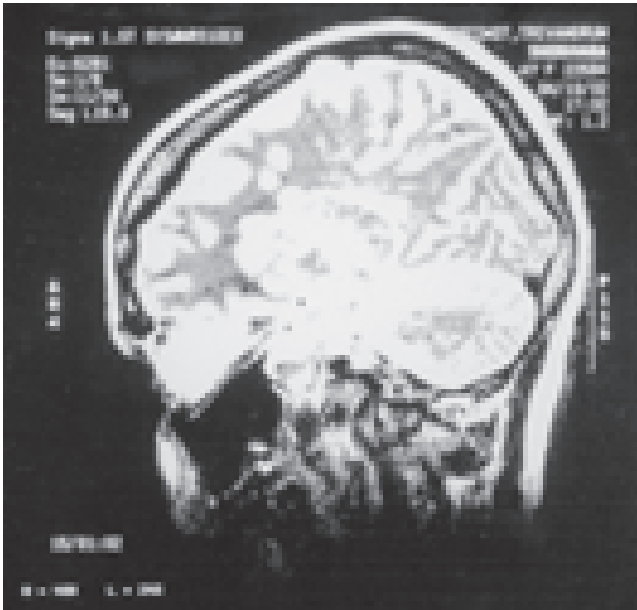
MRI T2 weighted image, sagittal section. Note multiple plaques in subcortical region and corpus callosum.
